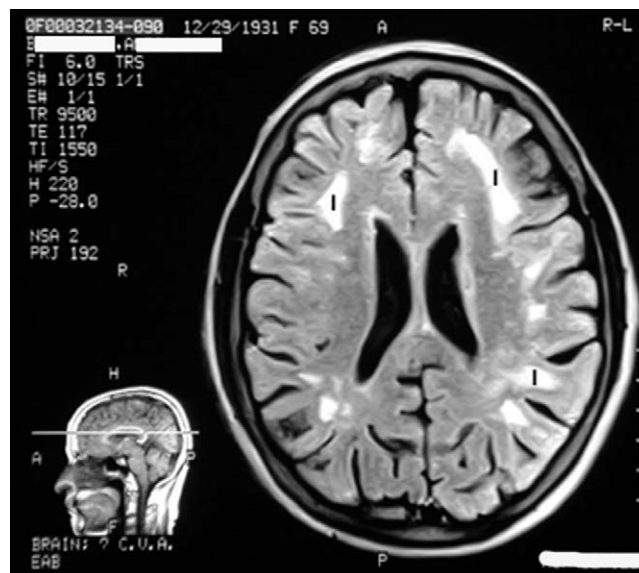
Axial MRI slice demonstrating areas of ischemia (i) in the patient's brain that originally led to the diagnosis of CVA.
